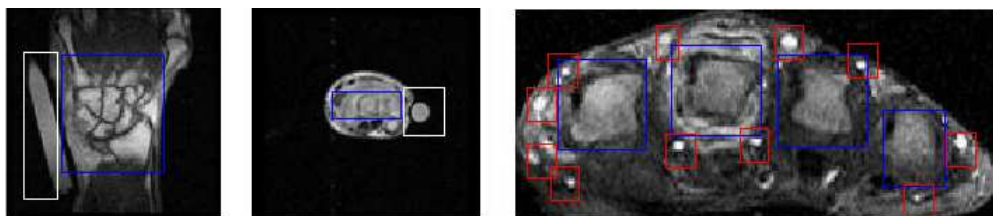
Left: MR image of wrist acquired by a low-field scanner. Middle: MR image of the MCP joints acquired by a low-field scanner. Right: MR image of the MCP joints acquired by a high-field scanner. In the images markers are marked by white rectangles, bones by blue rectangles, blood vessels by red rectangles.
